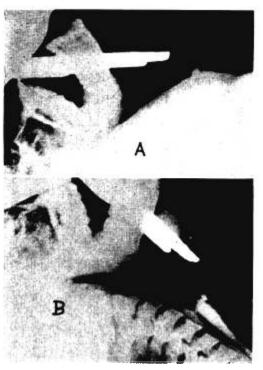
Lateral view roentgenograms of pharynx during direct laryngoscopy. (A) Occiput lowered. Angle between laryngoscope blade and trachea. (B) Occiput elevated. Laryngoscope blade and trachea in line.
